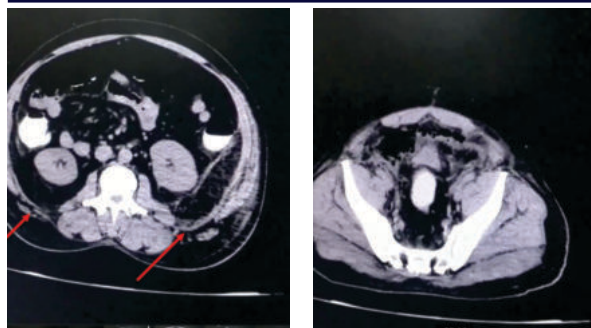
/3. CT Showing Mottled air and fluid collection in retroperitoneal space with Extension into pelvis below, and umbilicus anteriorly
